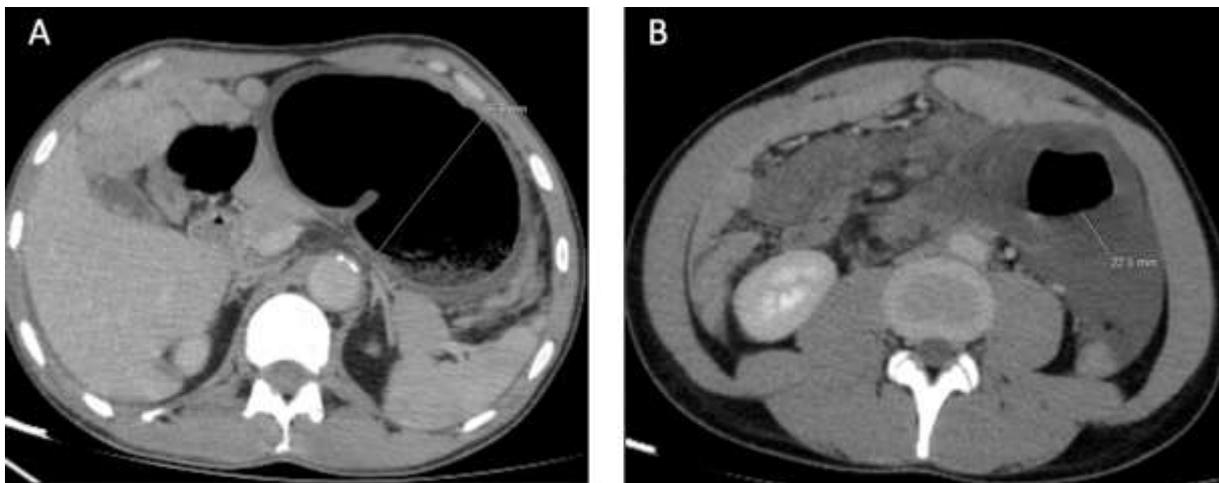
Axial CT scans at the portal phase of the first patient at two different levels: superior (figure A) and inferior (figure B), showing cecal distention in figure A (the lumen diameter measures 85.6 mm) and thickening with lack of wall enhancement in figure B (the wall's thickness is 22.5 mm)
